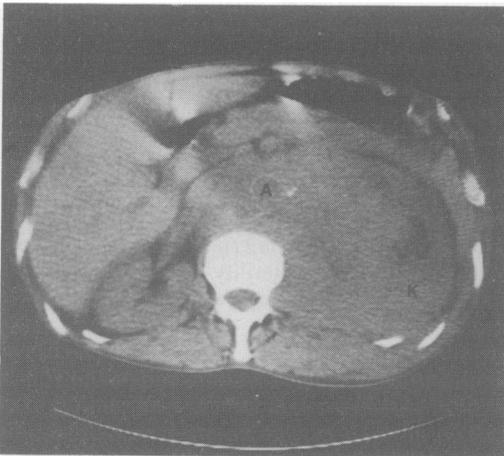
Non-enhanced CT demonstrates a large left upper quadrant mass, engulfing the aorta (A) with minimal wall calcification and a few spots of calcification in the left renal artery. The kidney (K) is displaced laterally merging with the mass.
